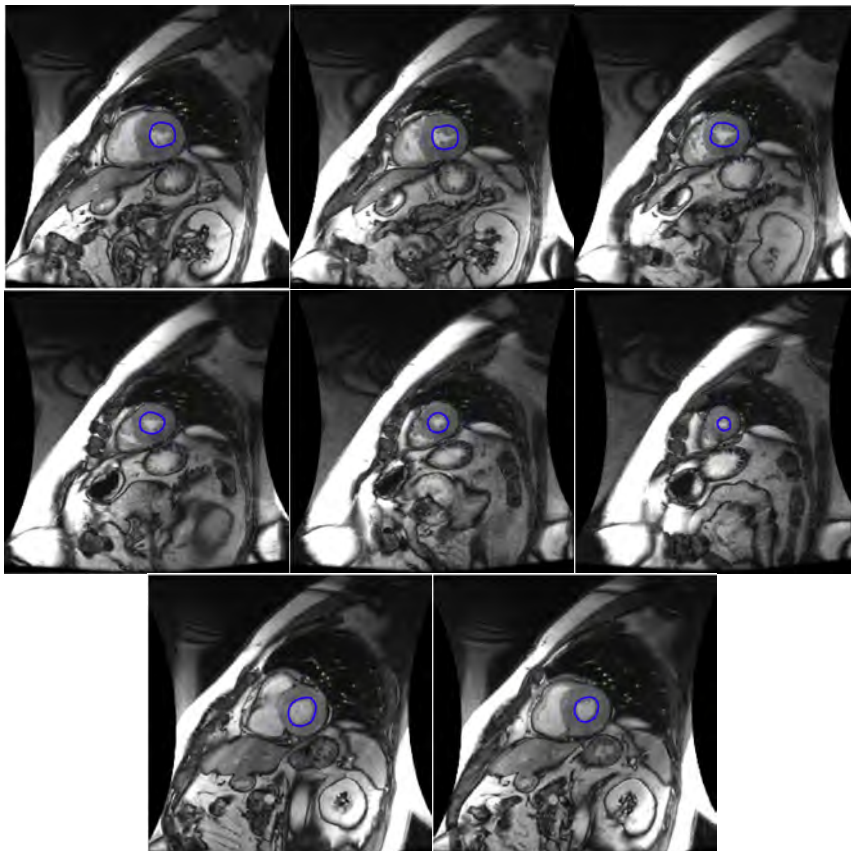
SAV MRI from SCD at the end systolic cardiac phase for a patient with no cardiac abnormalities with segmentation performed on left ventricle endocardium (blue contours)
